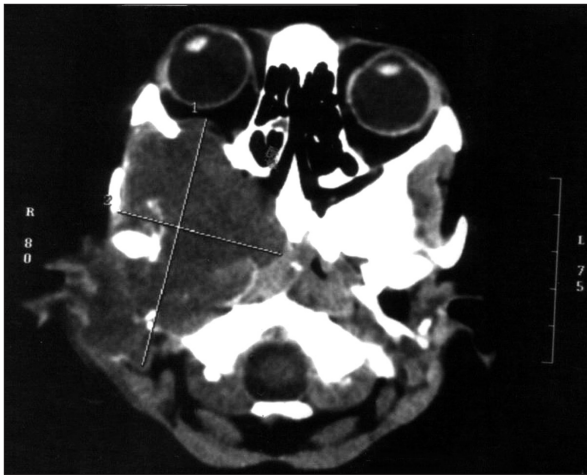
CT scan of a 5-year-old girl having embryonal rhabdomyosarcoma with extension into the orbit
